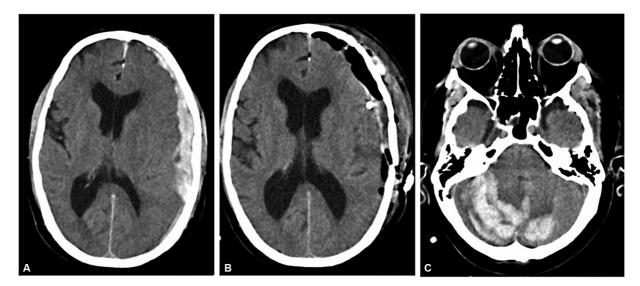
(A) Axial computed tomography (CT) scan revealing an acute subdural hematoma on the left cerebral (fronto-temporo-parietal) convexity, and mild midline shift. Additionally, there is sulcal effacement in the left cerebral hemispheres and mild compression of the left lateral ventricle. (B) Postoperative CT scan demonstrating the successful evacuation of the acute subdural hematoma, with a drainage tube remaining in place within the left subdural collection. (C) Postoperative axial CT image, revealing acute hemorrhage in the cerebellum, predominantly on the right side suggestive of remote site hemorrhage. This hemorrhage is associated with effacement of basal cisterns, compression of the fourth ventricle, and obstructive hydrocephalus.
